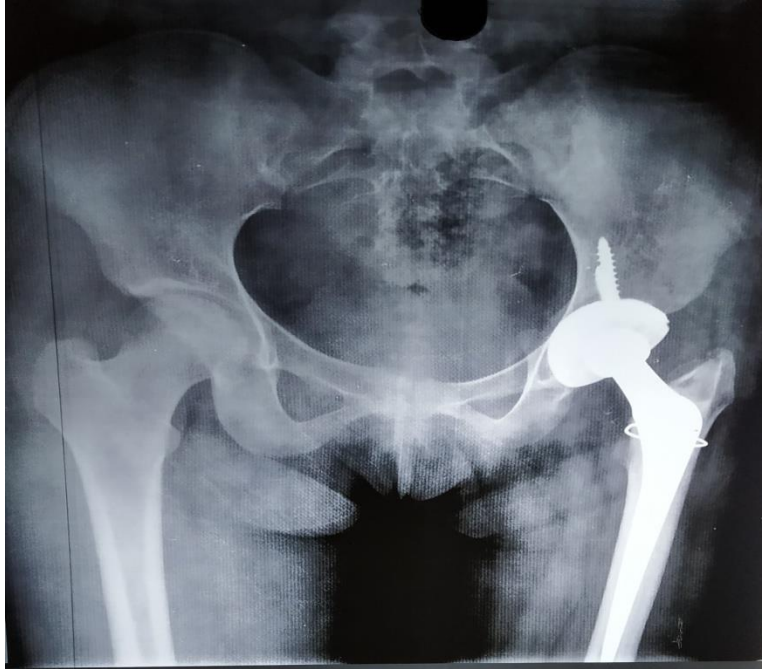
3 months Post operative follow up pelvic X-Ray of the patient after total hip replacement.
